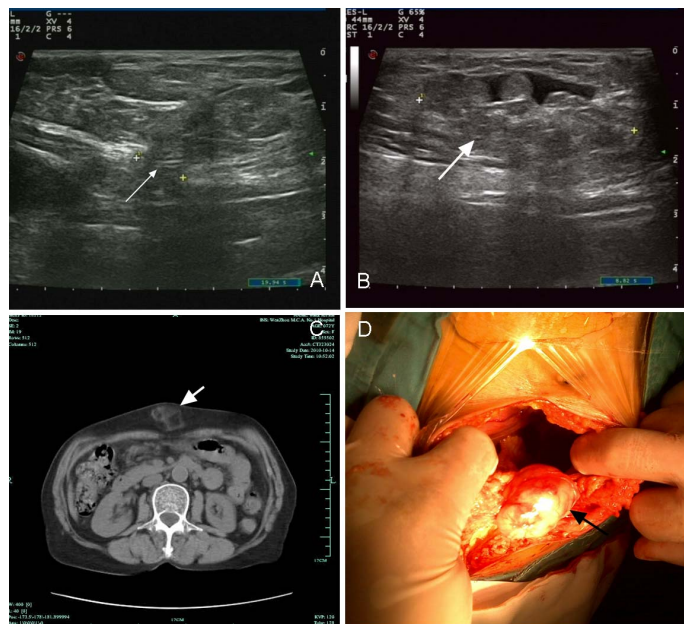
Ultrasound indicated that interrupted echo of deep fascia was found at epigastria, approximately 9 mm defect, and an slightly strong echo mass about 53 mm × 20 mm × 39 mm in size located at superior layers, and peristaltic bowel and omentum-like tissue in this space, connected with intra-abdominal cavity (A, B). CT scanning demonstrated fat-like tissues were found in abdominal wall of epigastric region, and lineal alba hernia was the first consideration (C). A clear, yellowish and soft lump about 3 cm × 4 cm × 4 cm was found in lineal alba, which it connected with hepatic round ligament (D)
